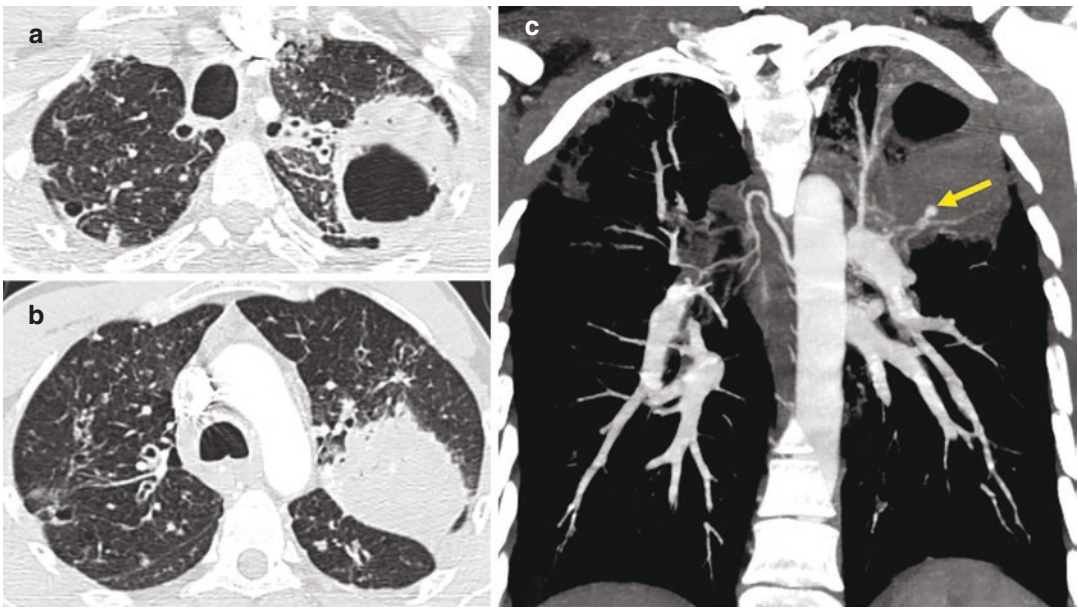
Rasmussen aneurysm in a 42-year-old man. (a and b) Axial contrast-enhanced CT images show active pulmonary tuberculosis with cavitating consolidation of the left upper lobe. (c) Coronal MIP-reconstructed contrast-enhanced CT image shows the Rasmussen aneurysm (arrow)
